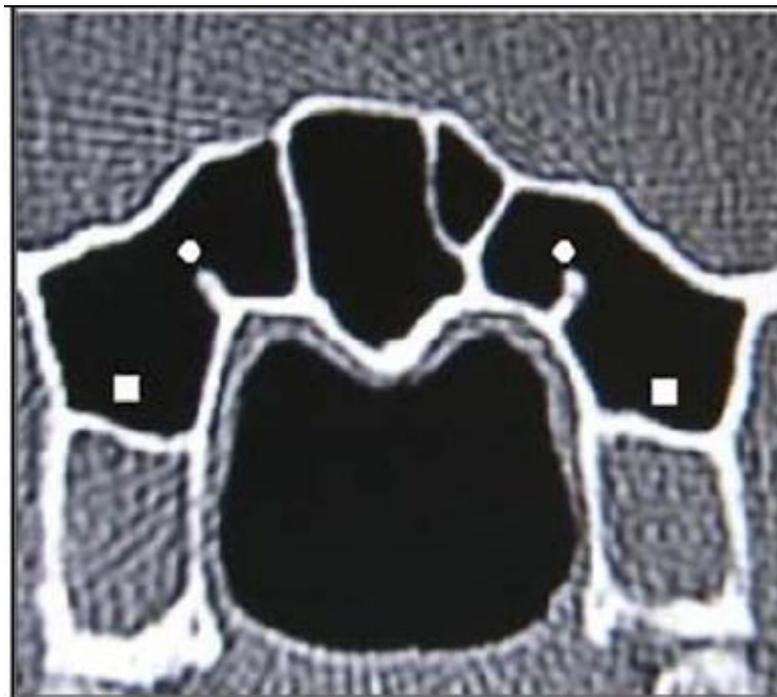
Coronal CT image showing pneumatization of pterygoid processes (squares), and protrusion of vidian canals (circles)
